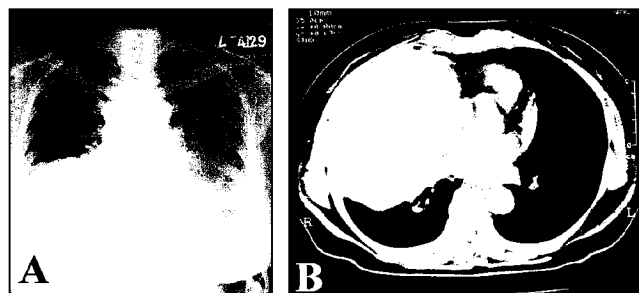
Chest X-ray showing a large opacity occupying the right hemithorax. Fig. 1B. Computed tomography of the chest showing a large mass arising from the mediastinum.
